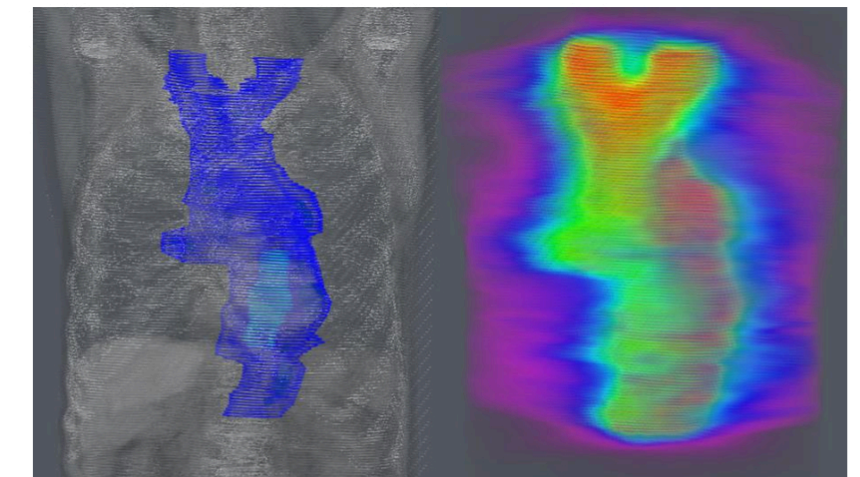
CT plan and total dose map
